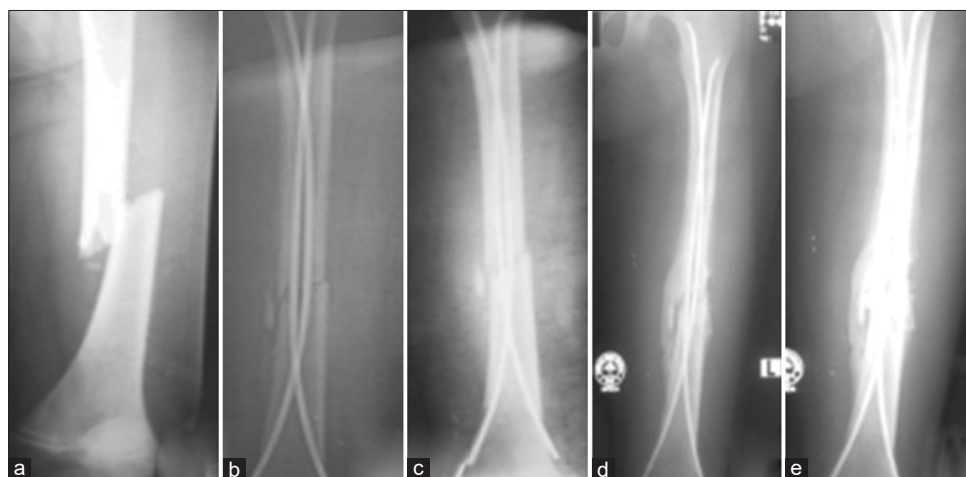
A 8-year-old male child was treated with TENS (a) Pre-operative X-ray, (b) just post-operative X-ray, (c) 1-month follow-up X-ray, (d) 2-month follow-up X-ray, and (e) 3 month follow-up X-ray
